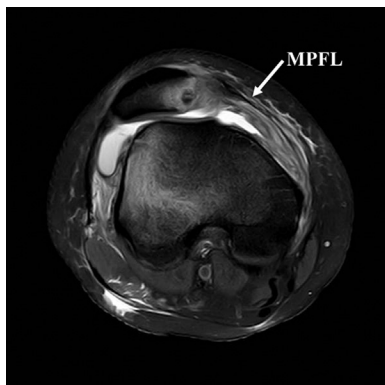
Axial T2-weighted magnetic resonance imaging view of the right knee joint. The medial patellofemoral ligament (MPFL) was completely ruptured, and the contusions of patella and lateral femoral condyle were obvious.
